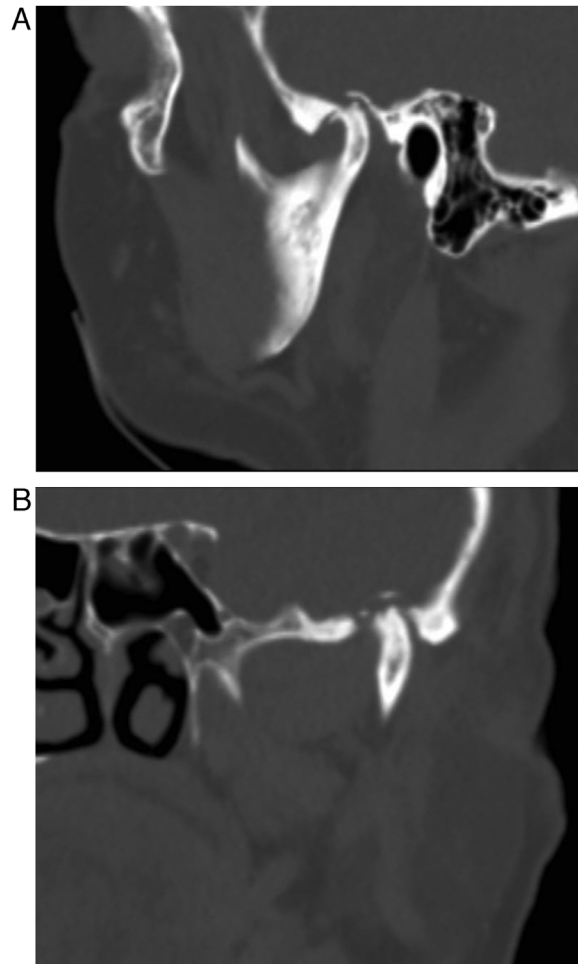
Computed tomography of the left temporomandibular joint depicting advanced degenerative joint disease. (A) Sagittal view: flattening of the articular surface, anteriorly directed osteophyte, and sclerosis, as well as a vertical intracranial displacement of the condyle in conjunction with an elevated bony shell. (B) Coronal view: elevation of a glenoid fossa fragment and left condyle towards the middle cranial fossa.
